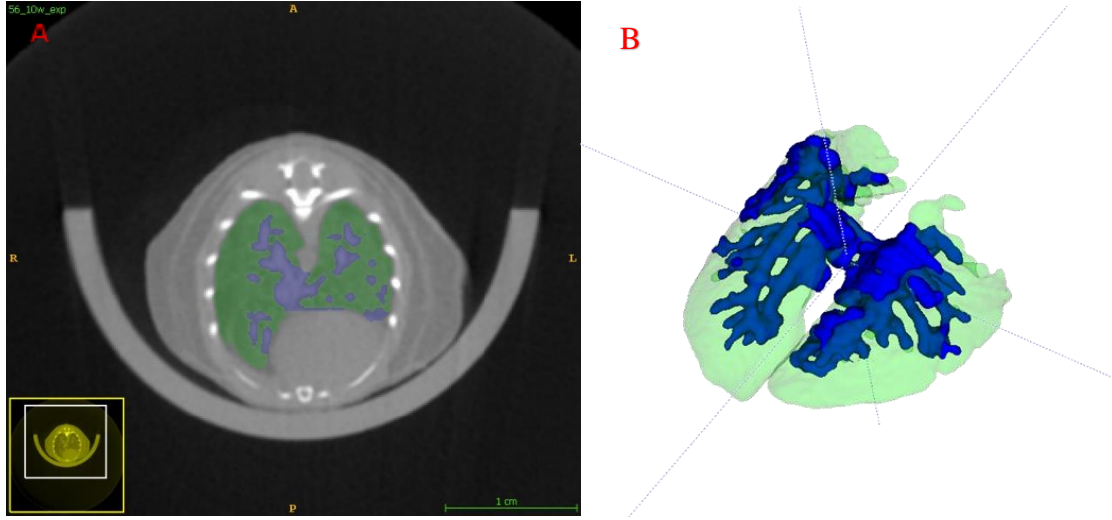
[A] Segmentation of CT image in the transverse plane. Segmentations were developed using a semi-automatic algorithm to label areas that were hypointense as “lung.” Hyperintense areas were then manually segmented as “fibrosis.” [B] Three-dimensional construction of segmentation. Areas that are green are “lung” and areas that are blue are “fibrosis.”
